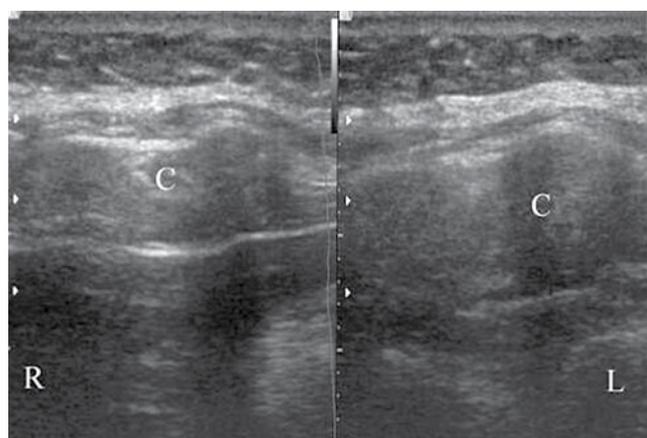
Comparative sonogram of costal arches. Costal cartilages (c), thicker on the left side (L)
